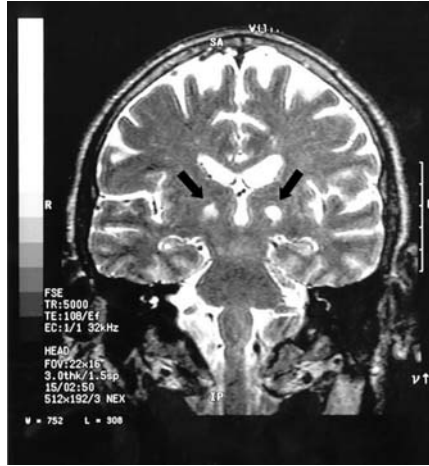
Coronal T2-weighted MRI brain scan which reveals bilateral lacunar-type infarcts (arrows) in the thalamic region.
